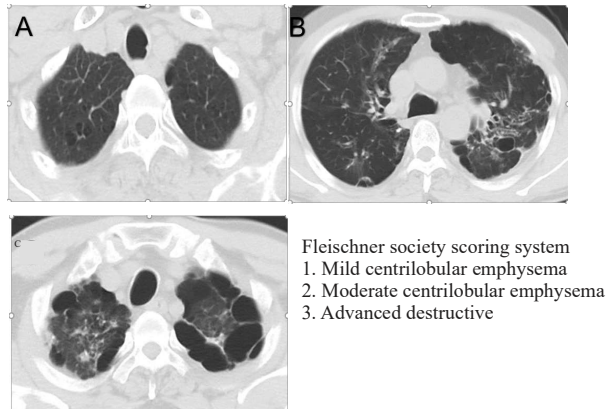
HRCT images showing Fleischner Society Scoring system
